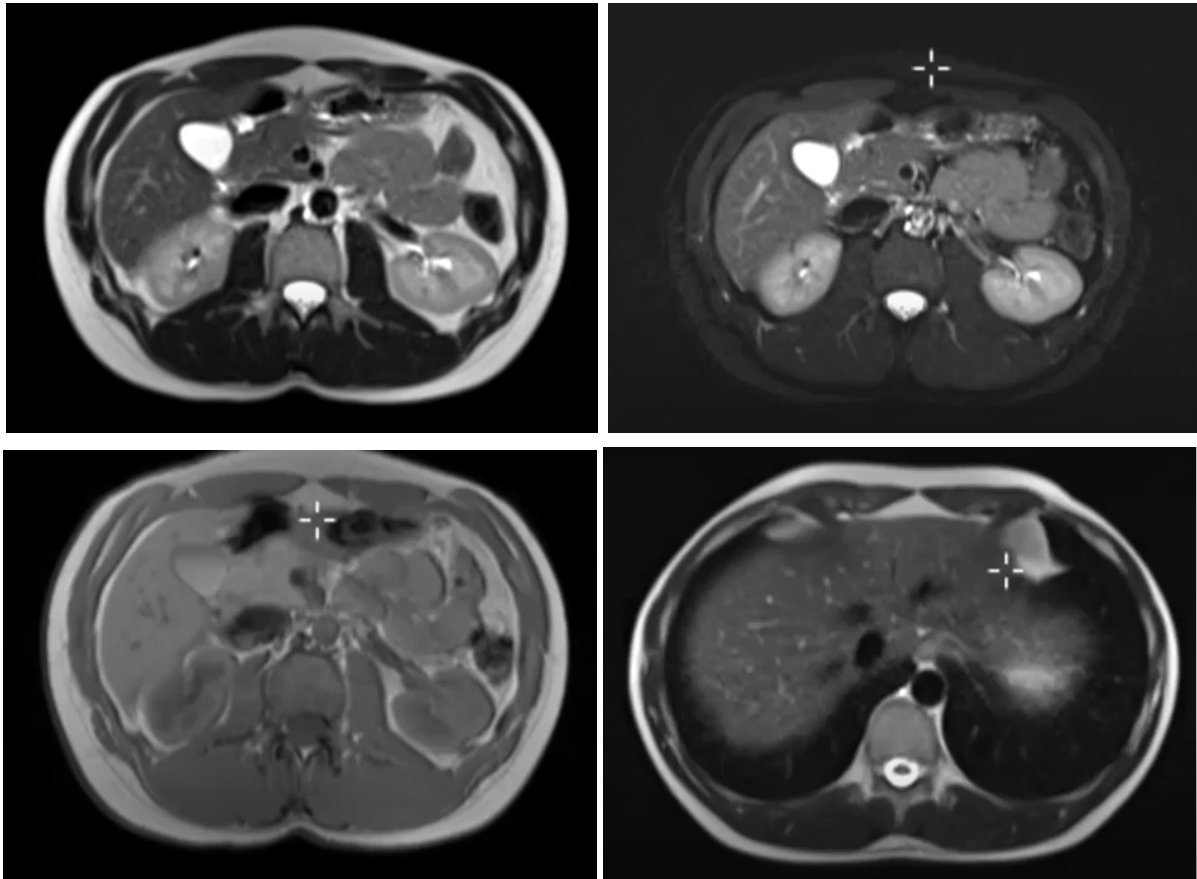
Liver MRI with contrast.
